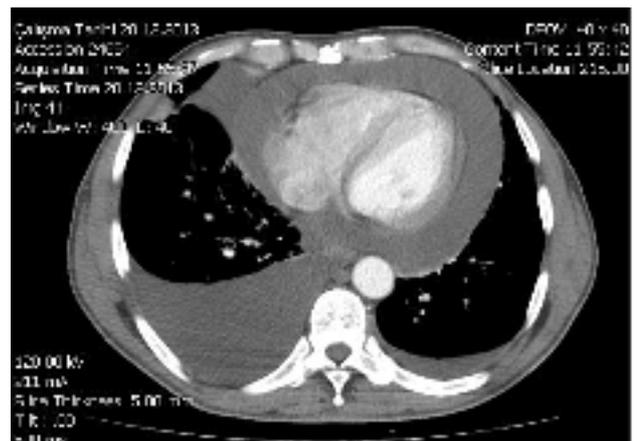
Chest computed tomography image demonstrating pericardial and bilateral pleural effusions.
